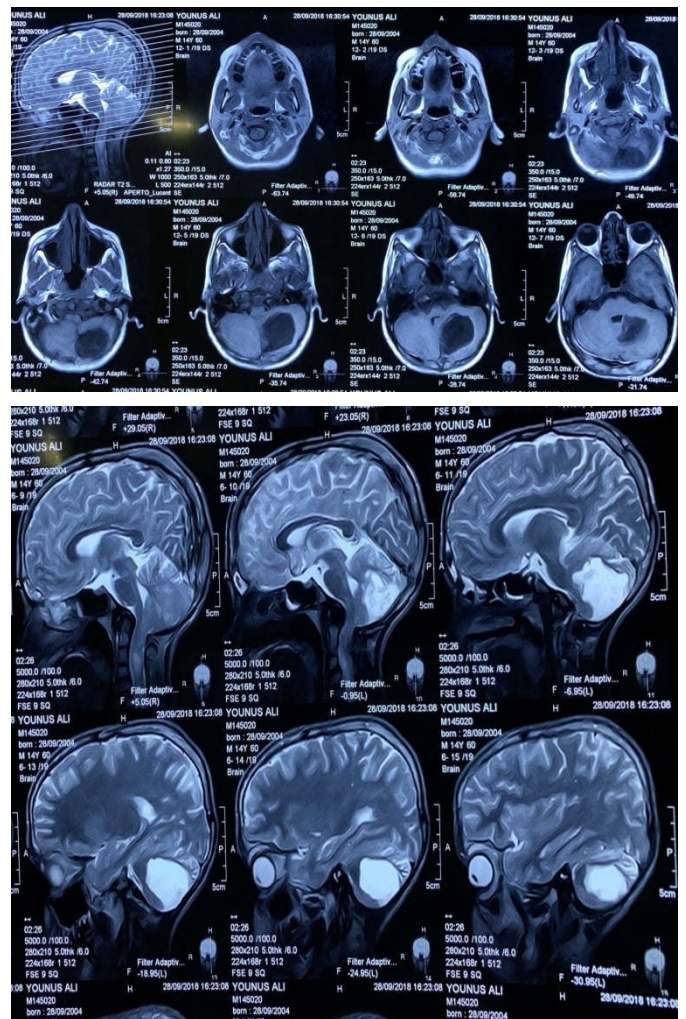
A & B: T1 & T2 weighted MRI of brain showed left cerebellar epidermoid
